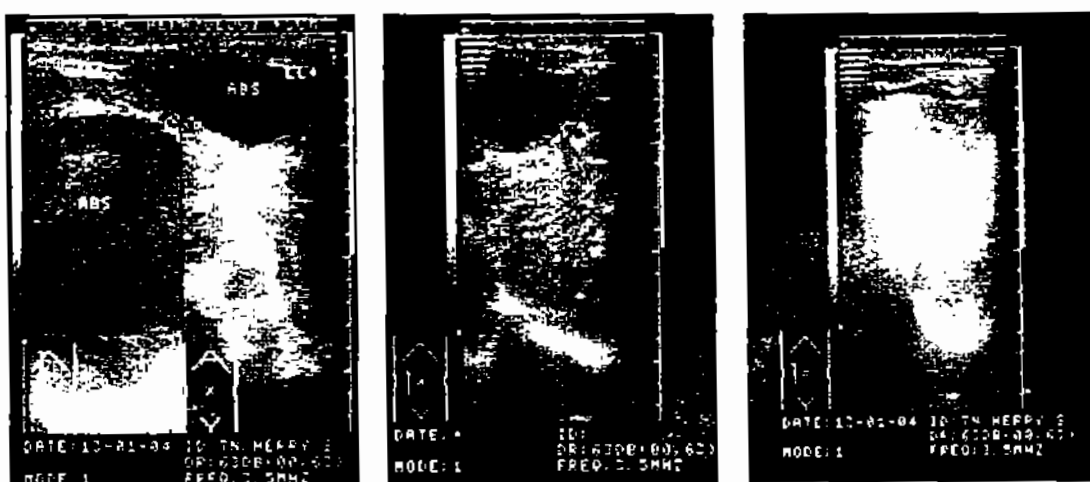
Abdominal ultrasound showed liver abscess after the second liver aspiration
